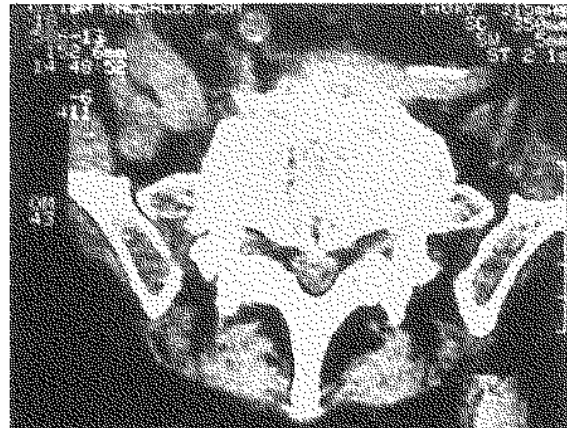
CT-Scan of the lumbosacral region of the spine 4 months after discharge from the hospital. The increase in the density of the lesions with calcification and stabilization of the process can be seen.
